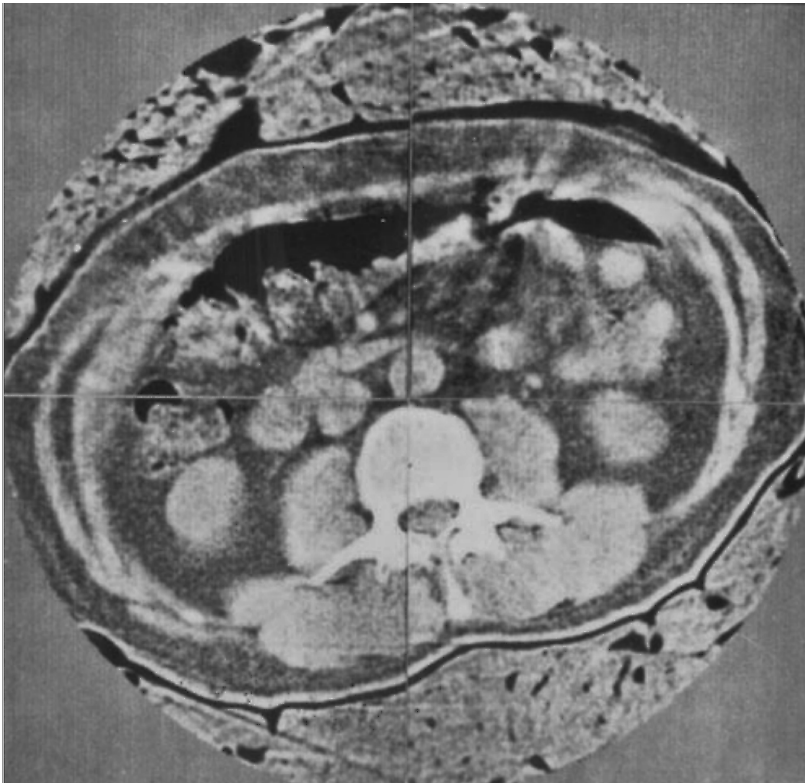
CT-scan of Godfrey Hounsfield's abdomen
